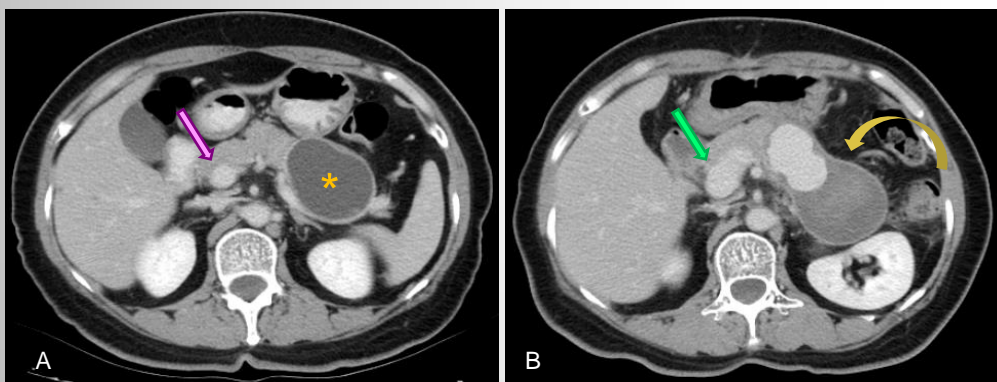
(A) Axial CT image before pancreatectomy shows well-marginated mass with low attenuation in tail of pancreas (asterisk). Also note the normal diameter of portal vein (pink arrow). (B) Axial CT image before pancreatectomy shows a partially thrombosed pseudoaneurysm (curved arrow) adjacent to neck of pancreas. The diameter of portal vein got enlarged (green arrow).
